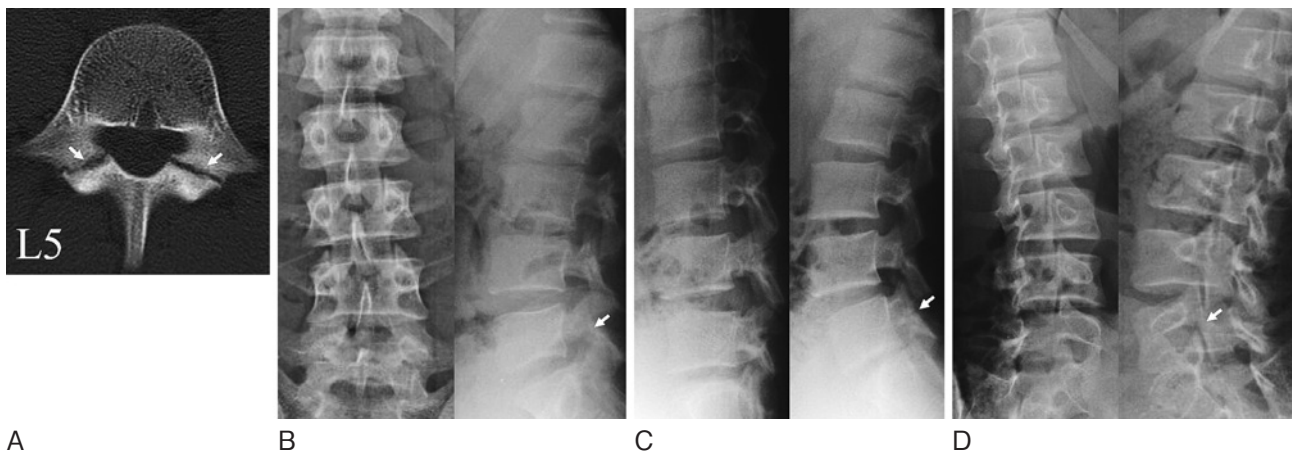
A reconstructed CT scan and plain radiographs for a 16-year-old boy with progressive spondylolysis. (A) An oblique-axial CT scan shows an obvious fracture line in the pars interarticularis (arrow). (B-D) Plain radiographs including anteroposterior, lateral (B), dynamic lateral views (C) on which the fracture line is not detectable, but dynamic lateral views (C) and oblique views (D), on which the fracture line is barely discernible.
